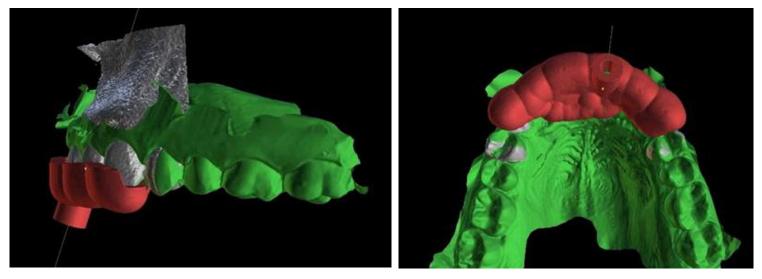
The range of the guide is drawn on the combined CBCT and STL image. This figure shows the extent of the template (a) Labially and (b) Palatally
